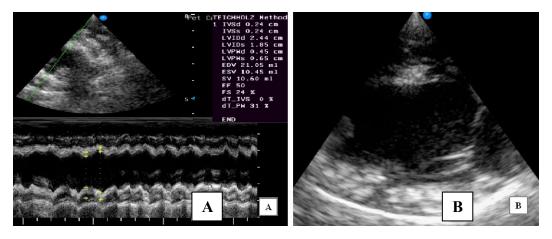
Echocardigraph showing A. Reduction of left ventricle EF (50%) B. Calcified areas on the LV posterior wall in the right parasternal long axis 4 chamber view
